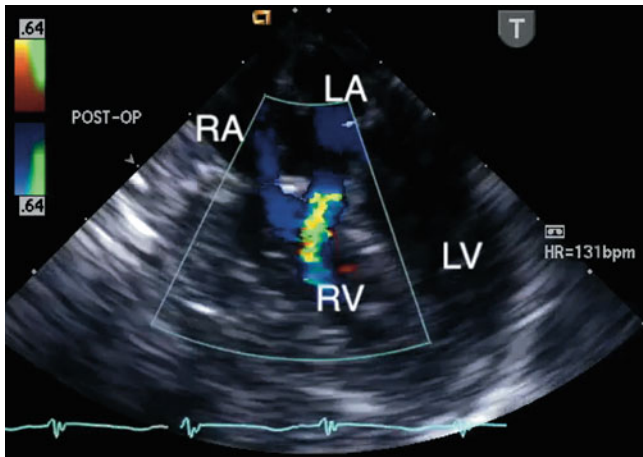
Postbypass transesophageal echocardiogram obtained in the mid esophageal four chamber view demonstrates flow by color Doppler from the left atrium (LA) into the right ventricle (RV; blue jet). This communication, representing a left-to-right shunt, was inadvertently created during repair of the defect. The echocardiographic findings led to revision of the repair. LV left ventricle, RA right atrium
